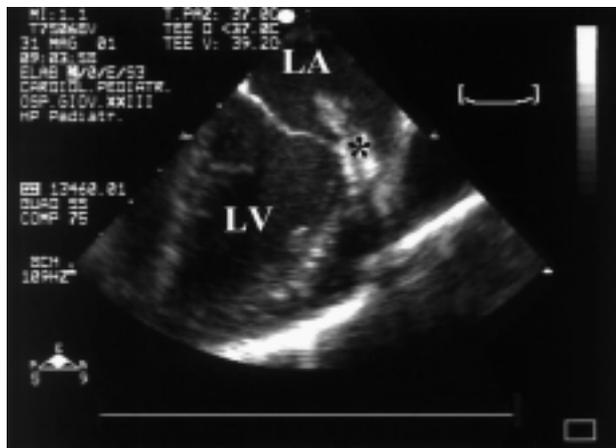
Transesophageal long-axis view showing the mass (*) in the left atrium (LA) attached to the lateral wall. LV = left ventricle.
